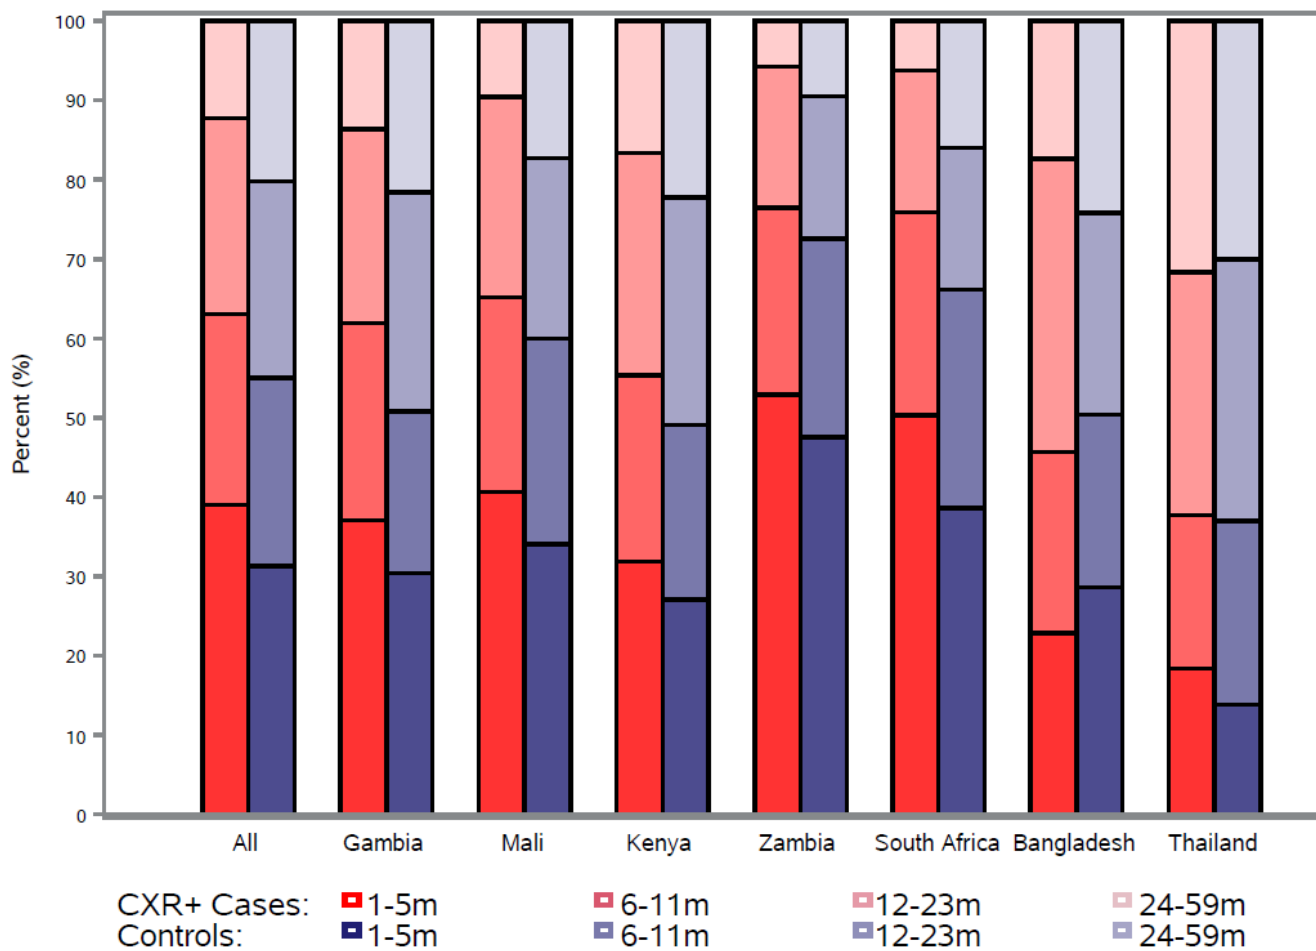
Abbreviations: CXR, chest radiograph; CXR+, abnormal CXR.
